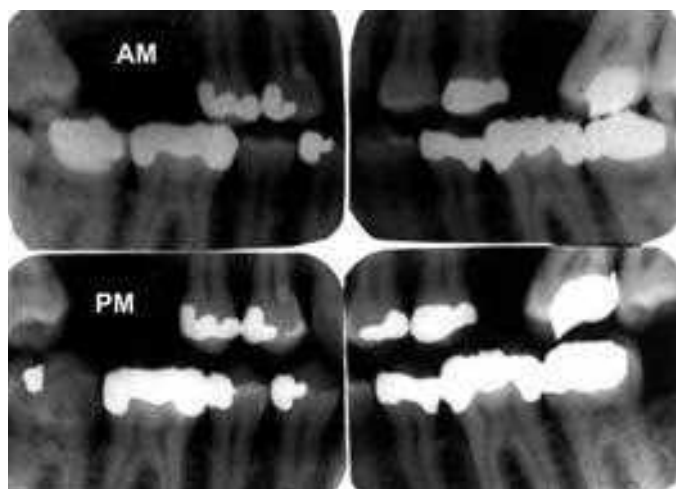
Antemortem (AM) and postmortem (PM) bitewing radiographs. The top two images are bitewing radiographs taken several years prior to death. The bottom two images were exposed on the body with a deliberate attempt to replicate and angulations of the antemortem (AM) images. There are discrepancies between the AM and postmortem (PM) images in terms of number of restorations, but they are explainable on account of the patient having undergone additional treatment in the interval between AM and PM examinations; the discrepancy in tooth 47 (lower right 2nd molar) is due to a dislodged restoration and fractured tooth, possibly due to trauma around the time of death. (Reprinted from Wood RE. *Forensic aspects of maxillofacial radiology*. *Forensic Sci Int* 2006;159S:S47–S55, with permission from Elsevier).
